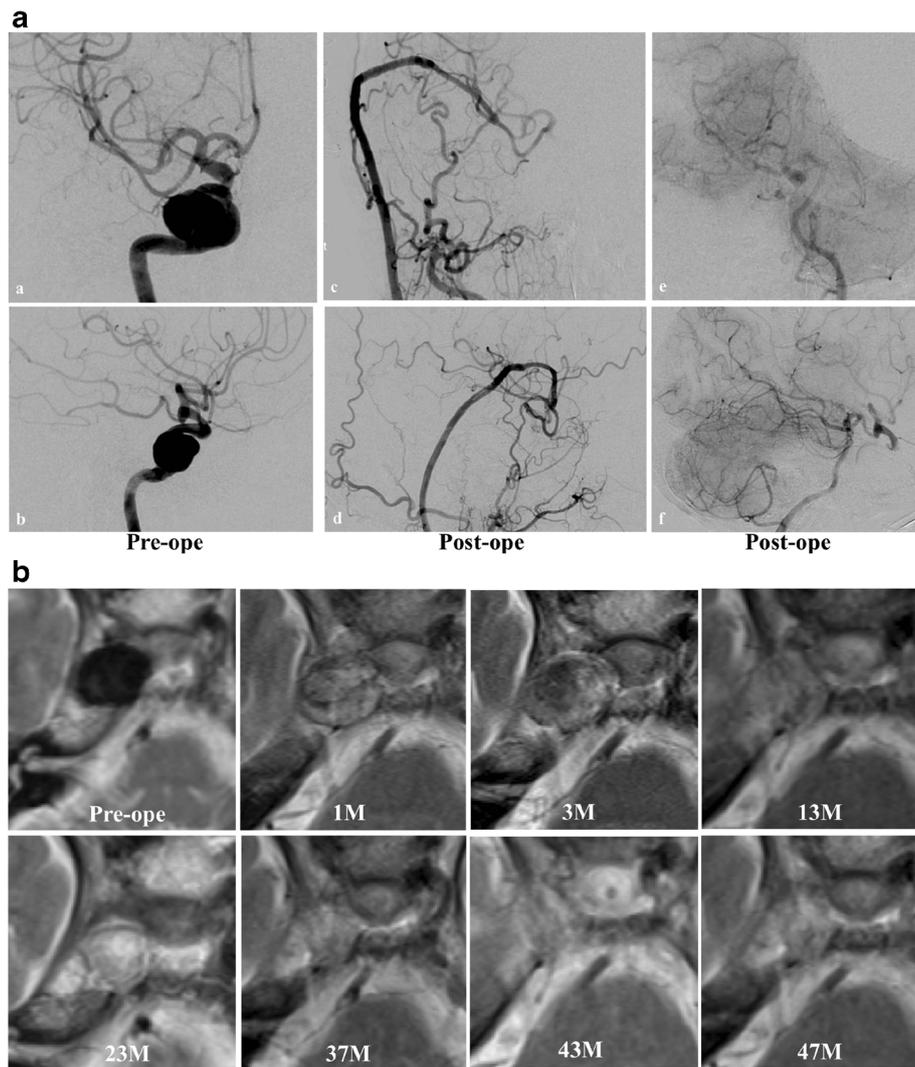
(A) a AP view of right ICA, b lateral view of right ICA, c AP view of right common carotid artery, d lateral view of right common carotid artery, e AP view of left VA, f Lateral view of left VA. (B) MRI T2-weighted images. (C) The black line is the transition graph of patient 1
